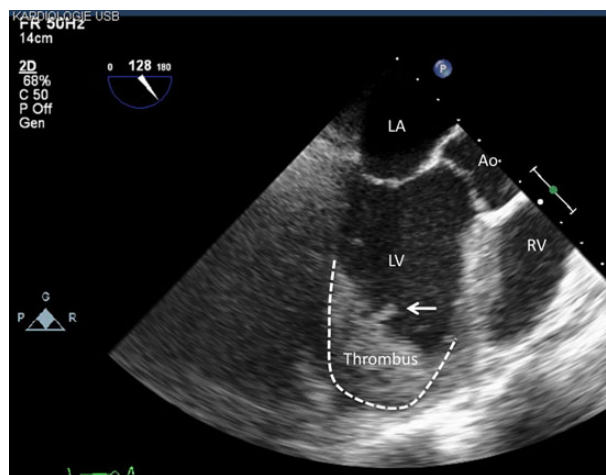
Transesophageal echocardiography: left ventricular apical thrombus. Abbreviations: Ao, aorta; LA, left atrium; LV, left ventricle; RV, right ventricle.
